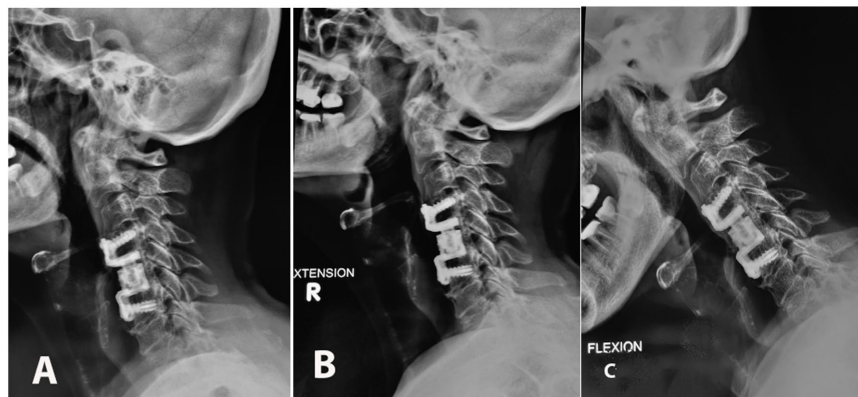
(A) Immediate postoperative lateral X-Ray films confirming an adequate position of the stabilizing device with expandable and bicortical anchorage of the screws. (B) and (C) Three months after the procedure, stability of the expansive cage is acceptable on dynamic films.
